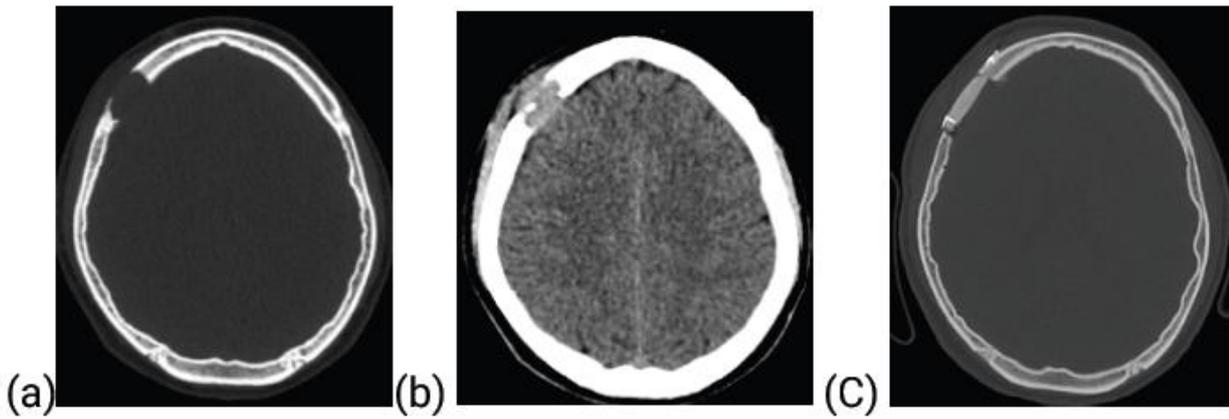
Eosinophilic granuloma: Axial sections cranial multidetector CT scan shows; (a) preoperative bone window with inner and outer table endosteal scalloping. (b) an osteolytic lesion of the right frontal skull with a subcutaneous soft tissue density mass. (c) postoperative bone window after cranioplasty with PMMA.
